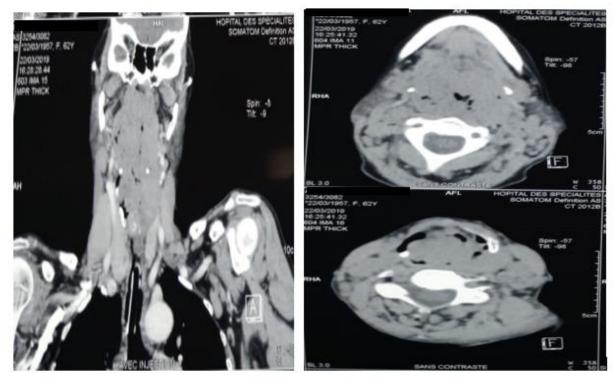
Cervical CT-Scan: tissue process in the posterior wall of the oropharynx, extending to the nasopharynx and hypopharynx
